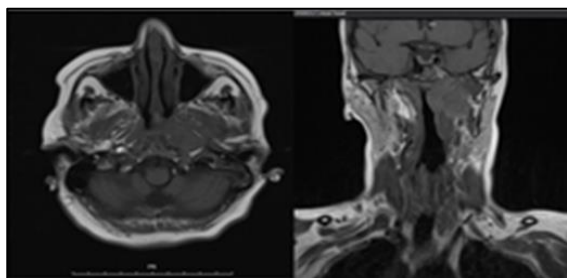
The axial and coronal T1-weighted MRI of the patient.
